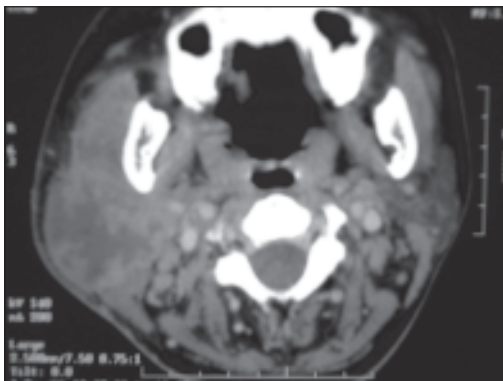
CT scan showed right parotid abscess with early extension to parapharyngeal space.
